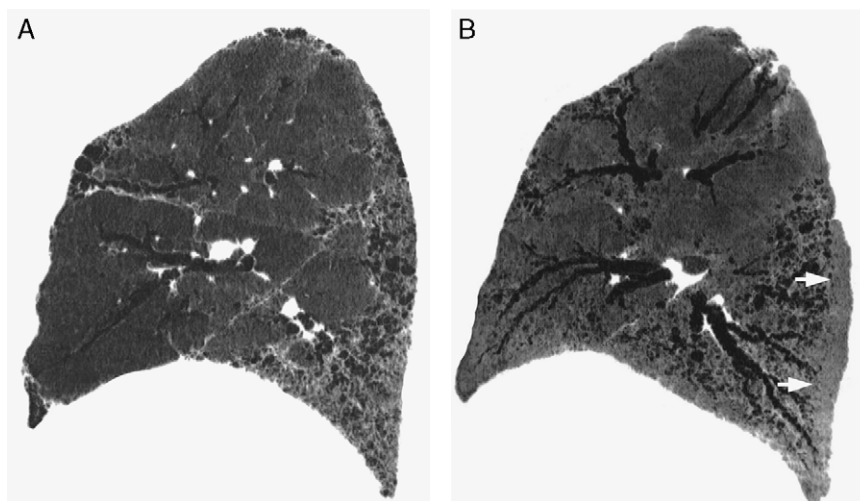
Usual interstitial pneumonia and nonspecific interstitial pneumonia: comparison of distribution in dorsal subpleural lung regions. A, Sagittal reformation minimal intensity projection HRCT image in a patient with usual interstitial pneumonia shows diffuse involvement of the dorsal lung regions. B, Sagittal reformation minimal intensity projection HRCT image in a patient with nonspecific interstitial pneumonia shows extensive reticulation and traction bronchiectasis in the lower lung zones, but sparing the immediately subpleural lung in the dorsal regions of the lower lobes (arrows).
